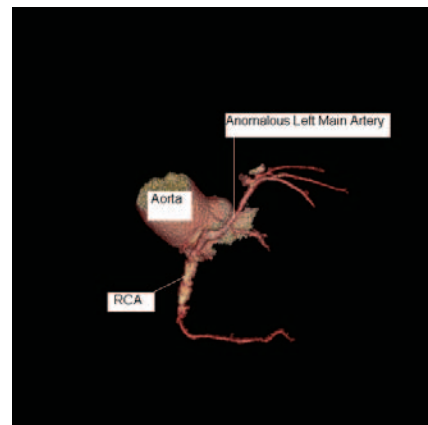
This image from 64-slice cardiac computed tomography shows an anomalous left main coronary artery arising from the right coronary artery (RCA). www.medreviews.com
